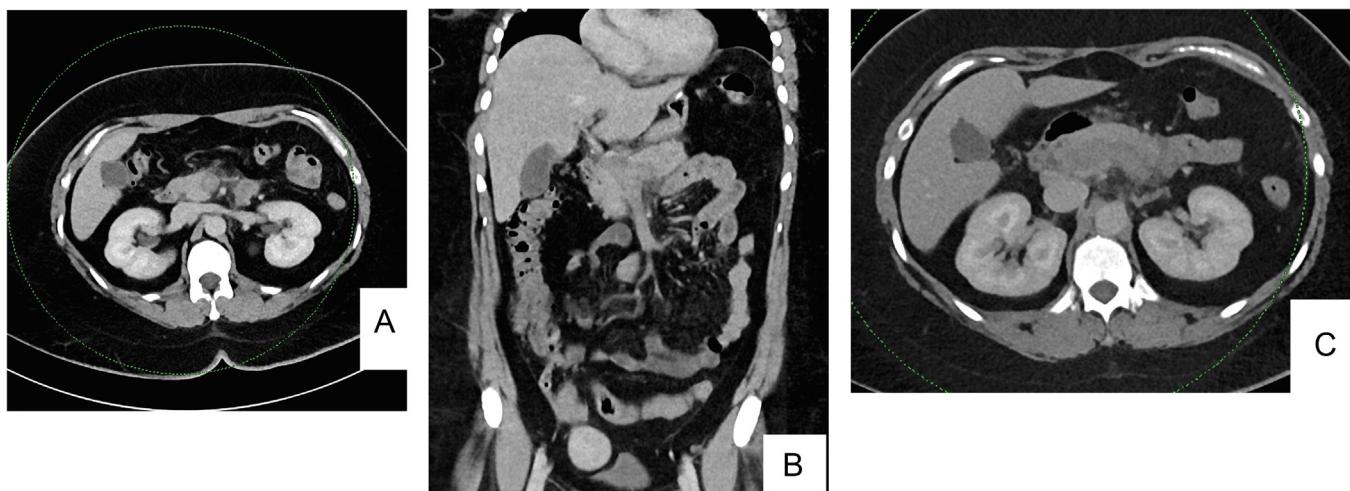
Selected contrast enhanced computed tomography of the abdomen at the level of the pancreatic head (a) and selected coronal and axial images (b and c) shows extensive filling defect and dilatation of the superior mesenteric, splenic and the portal veins associated with perivascular fat stranding.
